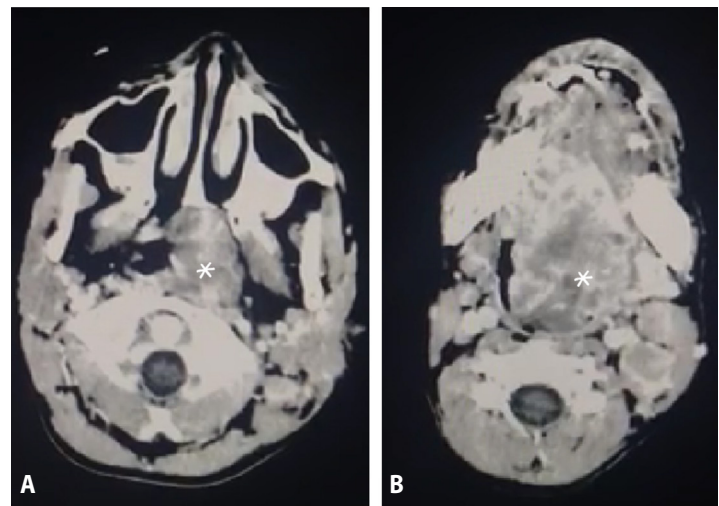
Contrast-enhanced CT images, axial views at the level of the: A. nasopharynx; and B. oropharynx; revealing a lobulated, heterogeneously enhancing soft tissue mass (asterisks) centered at the left tongue base, extending across the midline with infiltration of adjacent musculature and inferior extension toward the floor of the mouth, causing significant airway narrowing.
